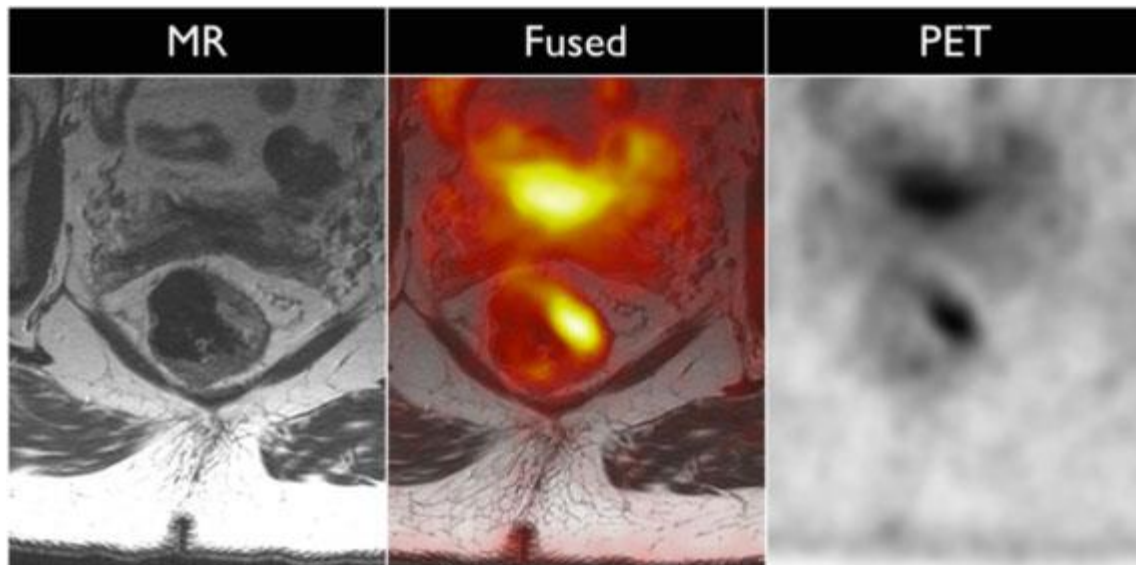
patient with newly diagnosed T2 rectal cancer. The mass is can be seen on MRI, but localization using PET imaging aids in localization. Additionally, the metabolic activity can be used to determine therapy response on serial imaging, and PET data can be used to detect distant metastasis.
